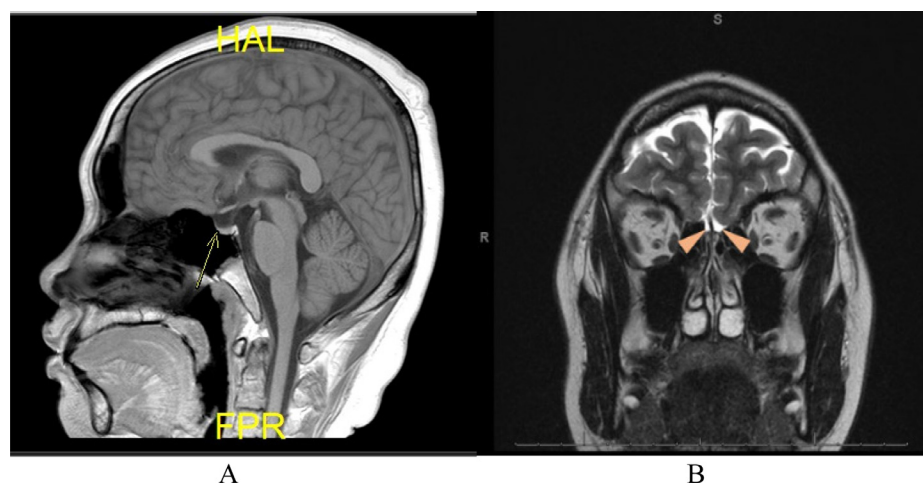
Brain MRI. (A) Pituitary gland hypoplasia (arrow), (B) an absent of the olfactory bulb (arrow).
